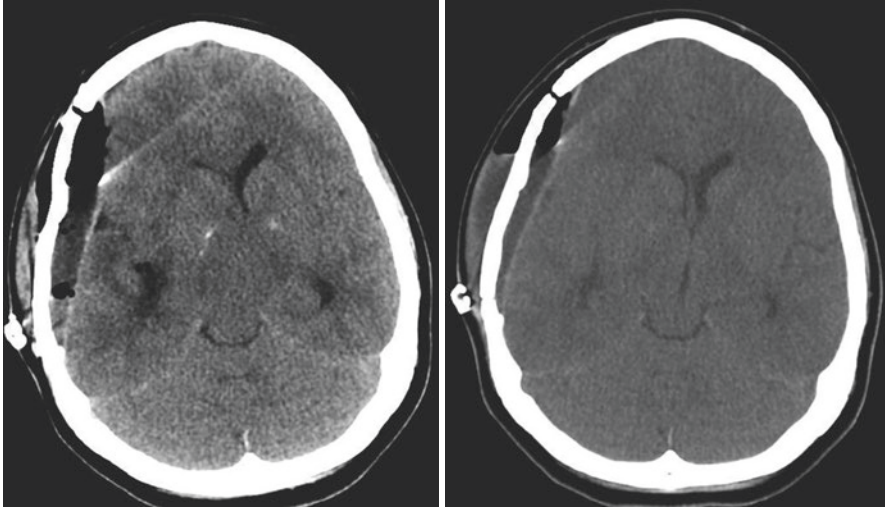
Noncontrast CT head showing an epidural fluid collection and air following craniotomy with lumbar drain (left). Following epidural blood patch, the patient's postural headaches resolved completely, and a post-procedure CT head performed 18 h later showed decrease in the collection (right)
